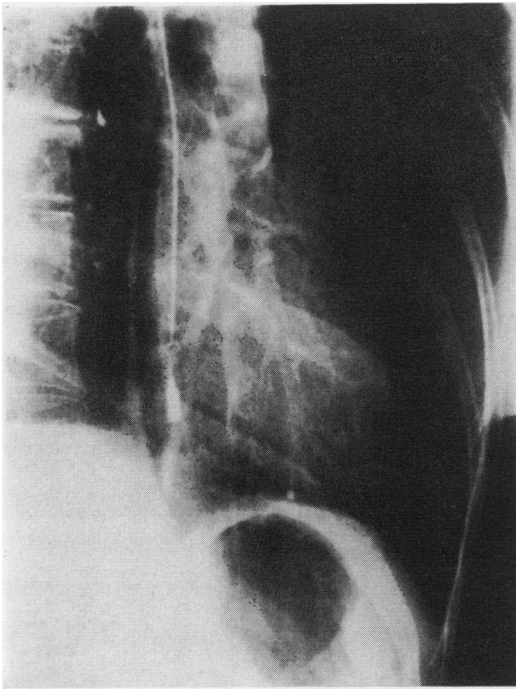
Oblique radiograph in the standing position. Alteration in the position of the electrode is seen here as in Figure 4.
